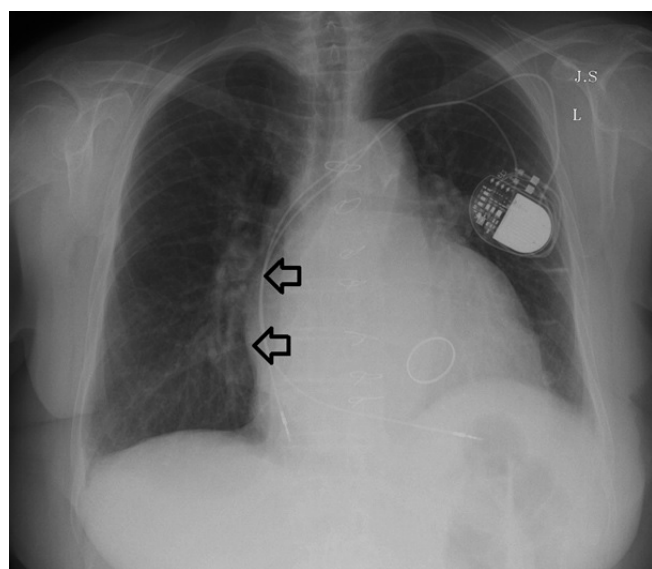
Chest radiograph in the antero-posterior view revealing marked prominence of the right cardiac border (arrowheads) consistent with left atrial enlargement.
